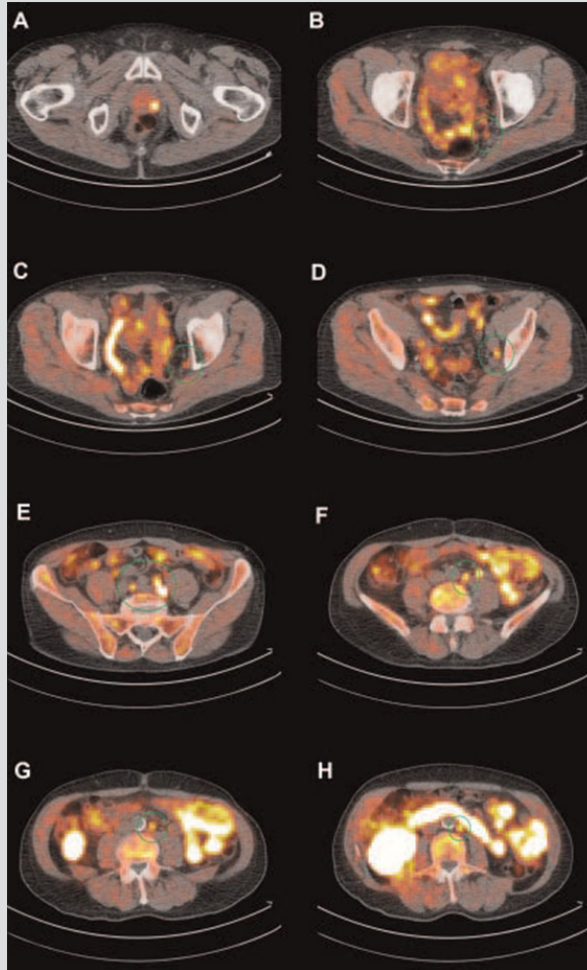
Transaxial slices of ^{18}F -choline PET/CT images of a patient with metastasized prostate cancer. Panel A shows local recurrence of prostate cancer in the left retrovesical area. Panels (B-H) show metastatic involvement of lymph nodes.
